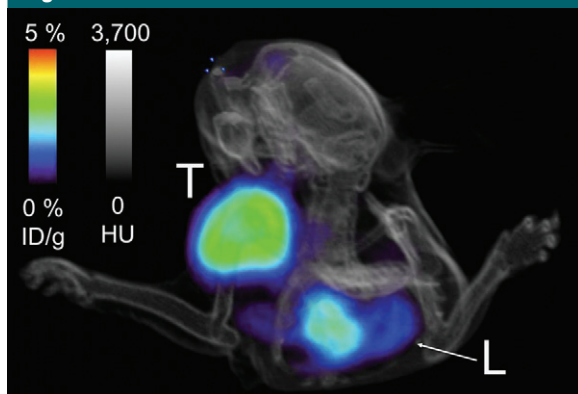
Micro-PET/CT image shows xenografted tumor (T) in the shoulder is clearly visible relative to background. L = liver.
